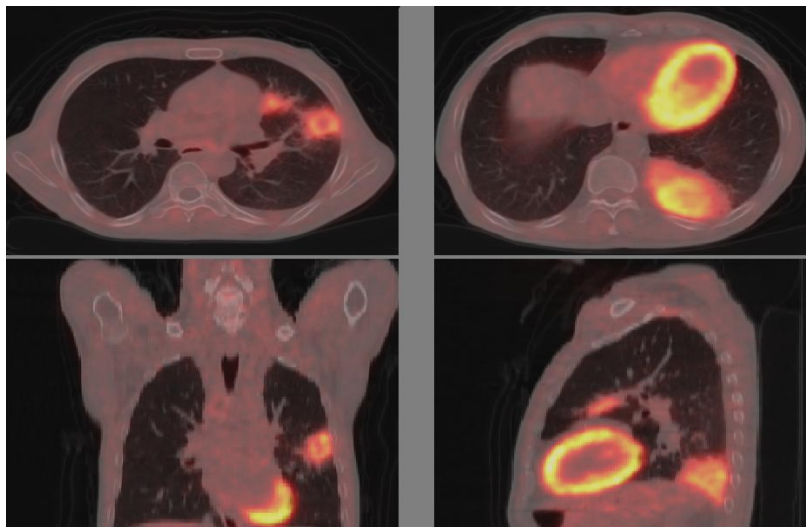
PET- CT scan. Hypermetabolic lesions of the lingula and left posterobasal segment
